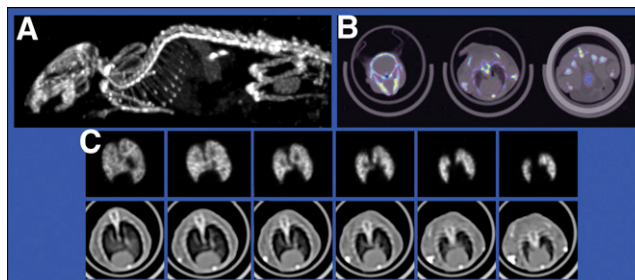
Images obtained with the device shown in Figure 19, including ^{99m}Tc-MAA lung micro-SPECT slices (C, top), coregistered CT (C, bottom), bone microSPECT (A), and micro-SPECT/CT (B).
